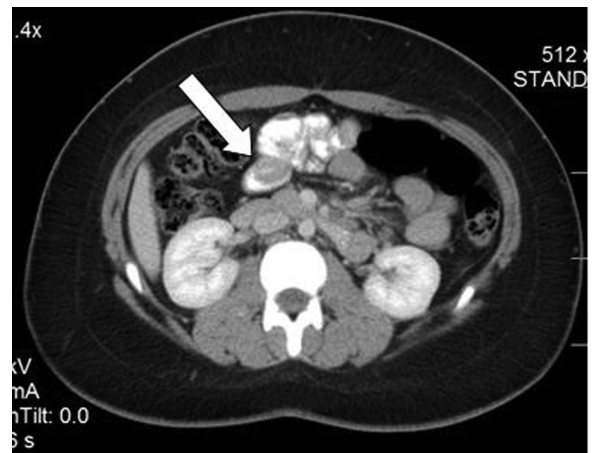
CT Abdomen/Pelvis with IV and oral contrast.
